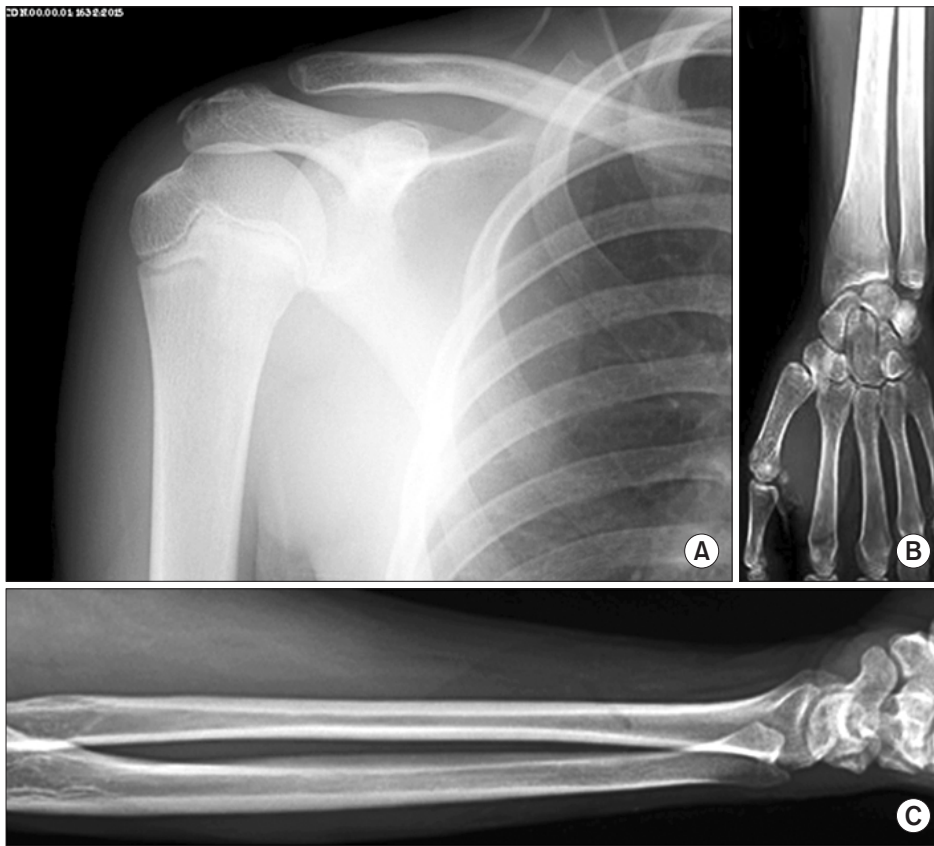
Final follow-up X-rays showing no observable deformity of the limb at 6 months after discharge. (A) Ipsilateral humerus. (B) Distal radial limb. (C) Supracondylar limb.
